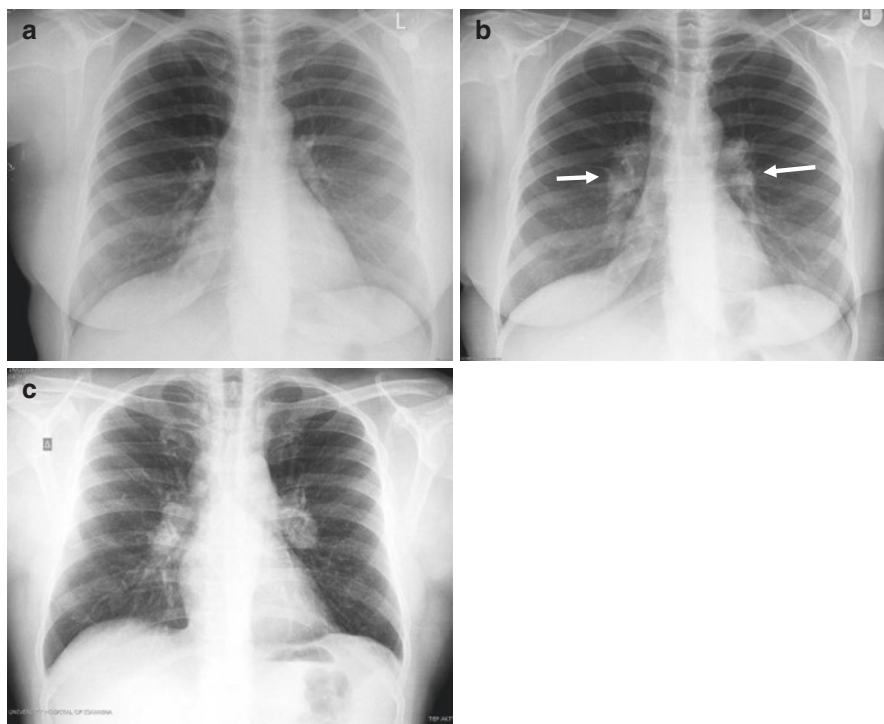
Radiographic manifestations of Sarcoidosis – Pulmonary sarcoidosis
